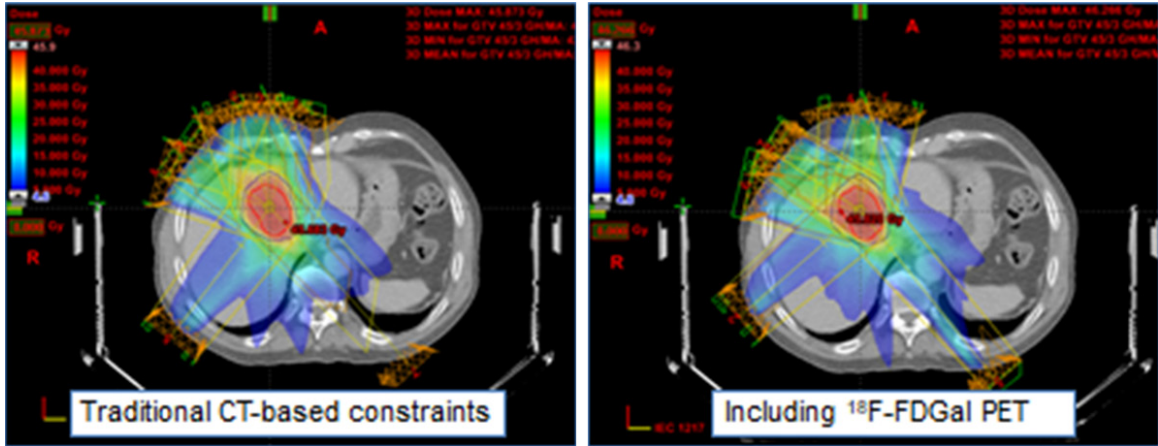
Example of how functional treatment planning using ^{18}F -FDG PET/CT significantly reduced the radiation dose delivered to regions with the best functioning liver tissue in a patient with colorectal liver metastases.
